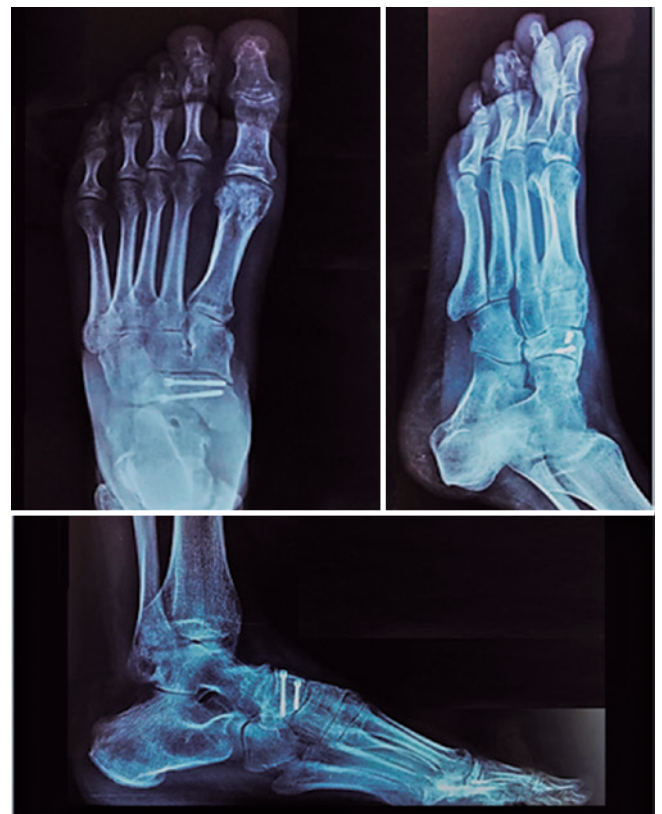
Radiographic views of the foot 10 months following the injury, 6 months after plate removal.
